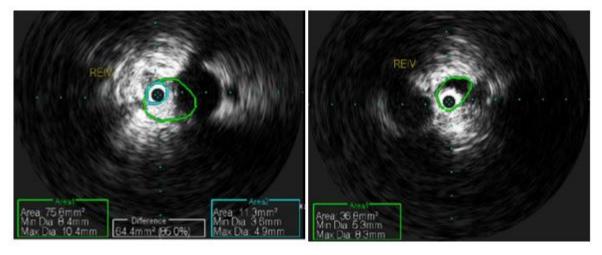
intravascular ultrasound showing severe stenosis of right external iliac vein
